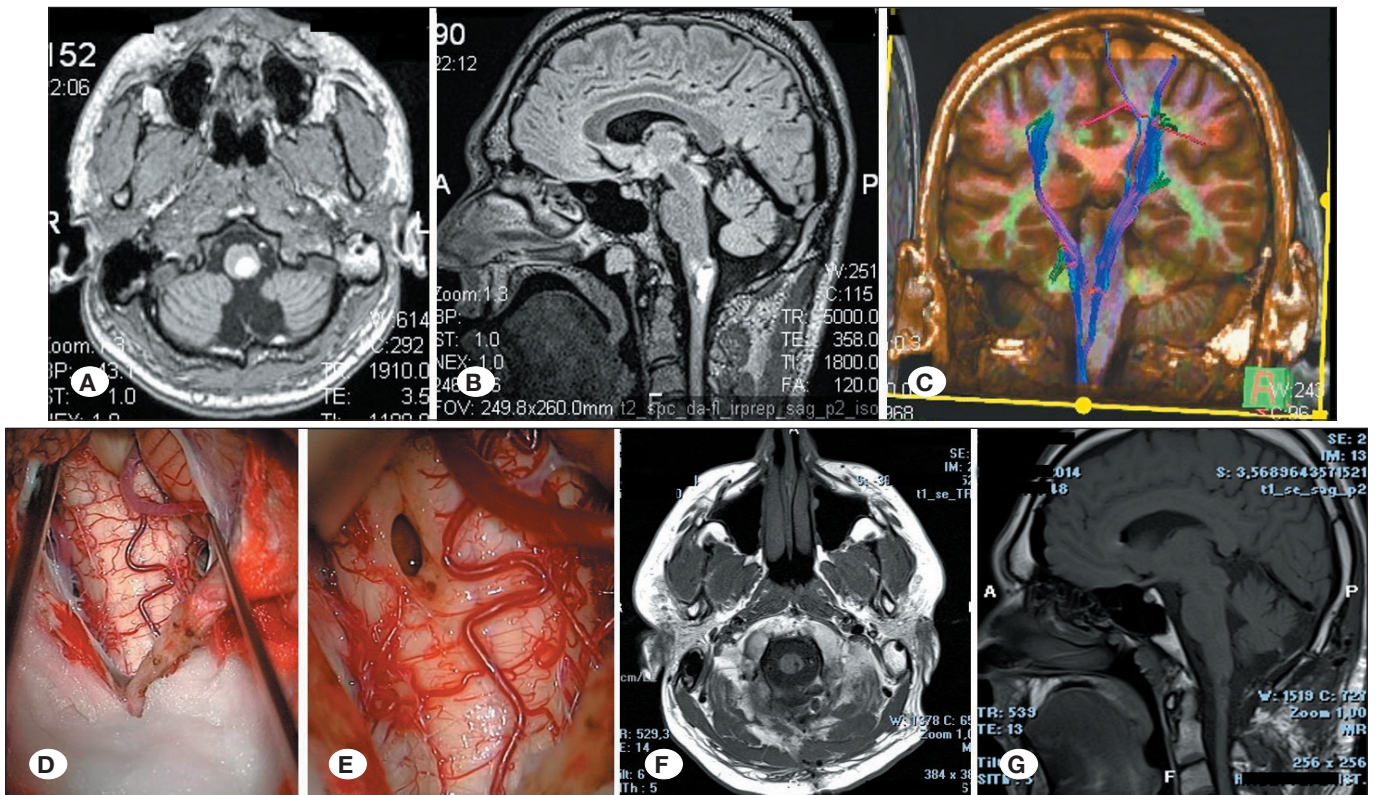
Case #18. A) T1-weighted axial magnetic resonance imaging (MRI) shows a cavernoma on the left dorsal surface of the medulla oblongata, B) sagittal MRI, C) DTI-tractography shows displacement of the pyramidal tract, D) the dorsal surface of the medulla oblongata was entirely normal, E) the cavernoma was excised with a small incision but the hemosiderin ring was left intact, F) axial, and G) sagittal T1-weighted postoperative MR images showed complete resection.
